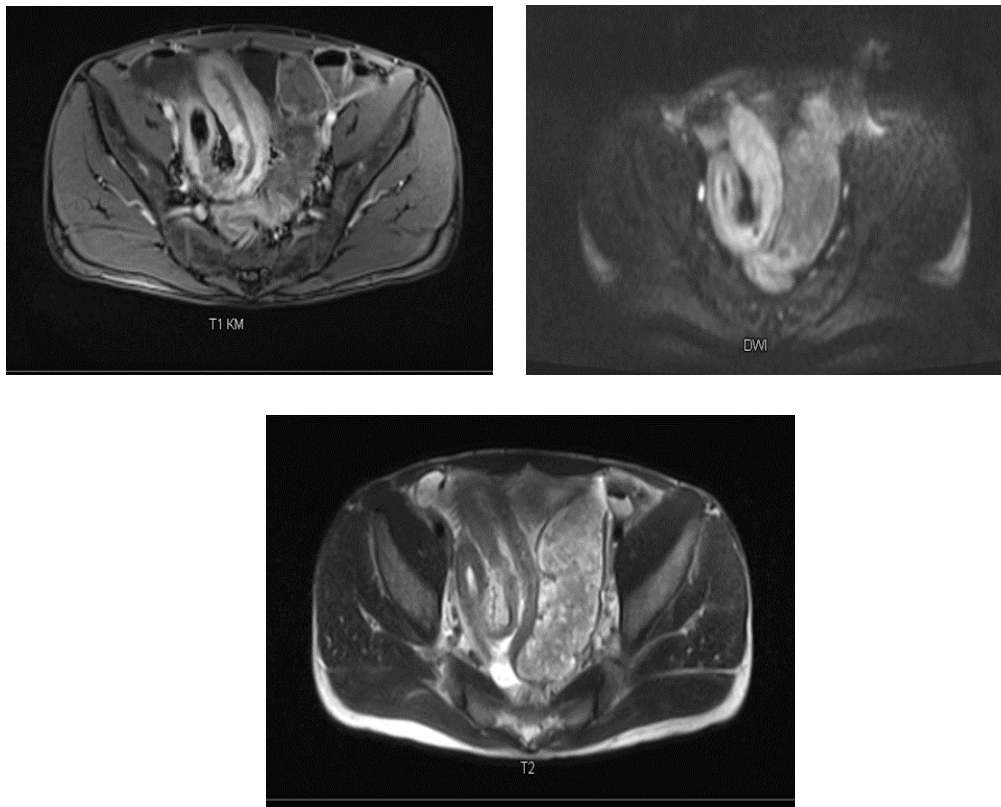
MPE showing wall thickening, postcontrast enhancement, DWI restriction, and free fluid around a T1 postcoel bowel loop. A T1 with contrast; B DW; C T2.
